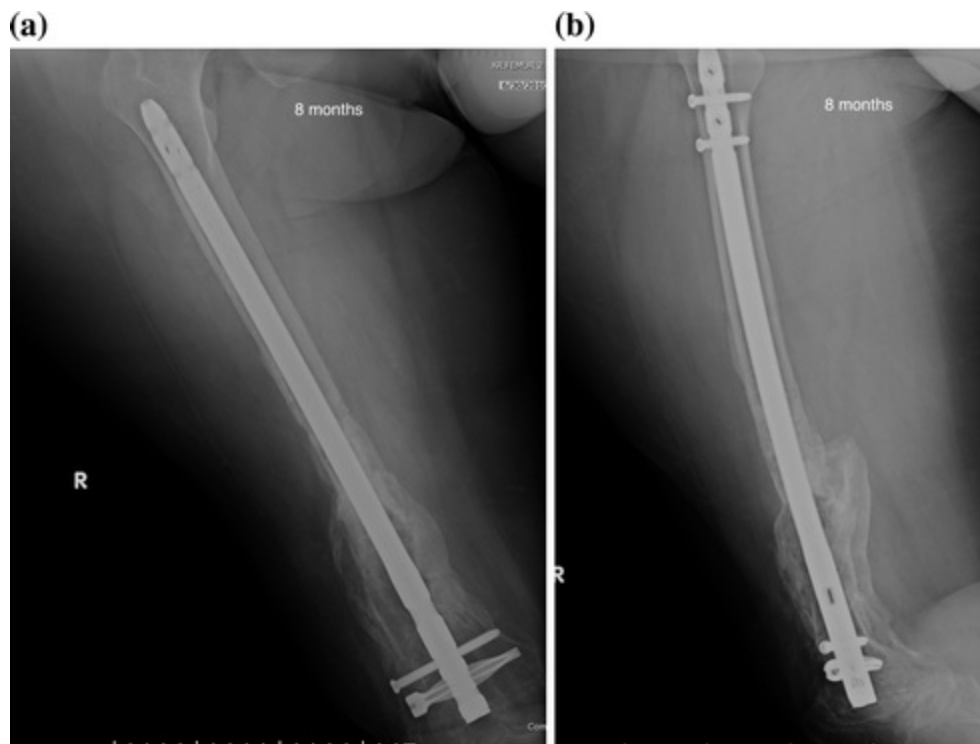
a Anteroposterior and b lateral radiographs of the right femur at 8 months showing complete bridging of all 4 cortices and stable hardware
